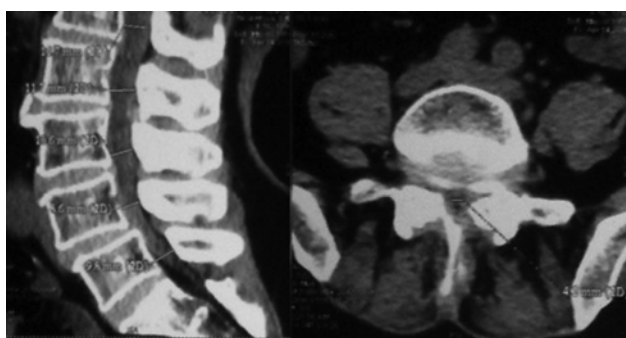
CT scans of a female patient T. with combined LSS due to stable degenerative anterolisthesis of L4 showing (a) pre-operative manifestations, (b) spinal canal enlarged postoperatively
